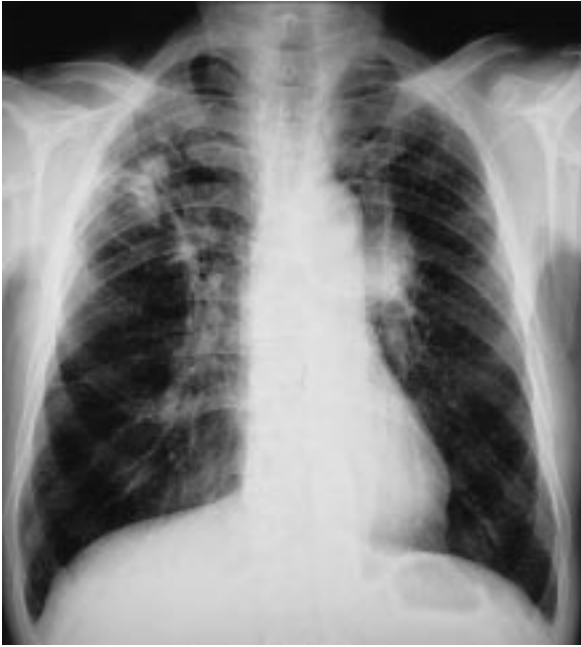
This figure shows the chest x-ray at his admission.
